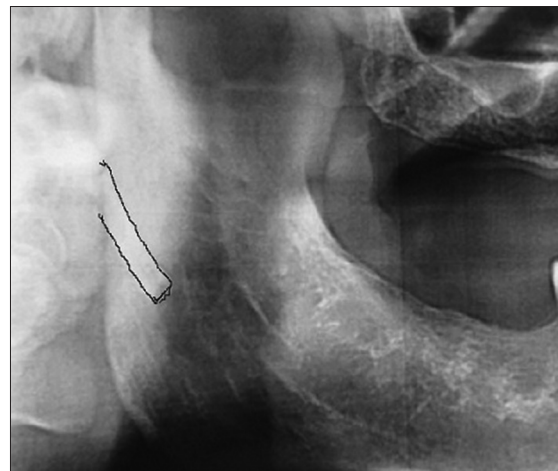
Preoperative orthopantomogram showing elongated styloid process
